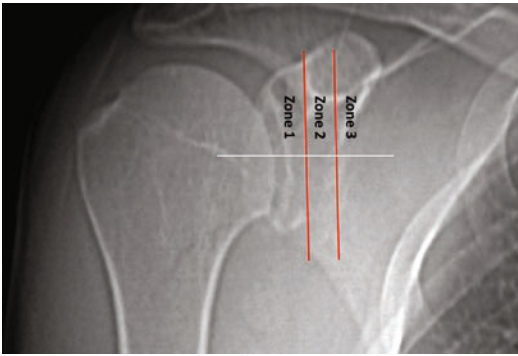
Radiographic classification of glenoid medialization according to Kocsis et al. [15]
